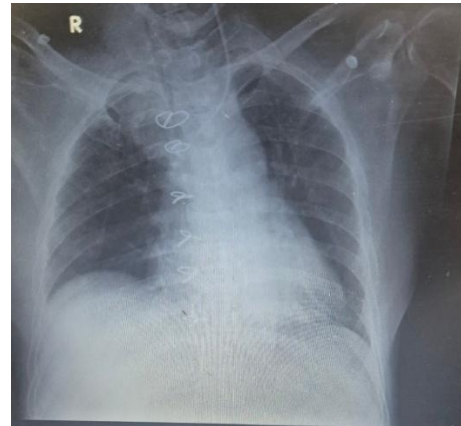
Chest X-ray AP view of patient showing complete resolution of pericardial effusion on day 7.
